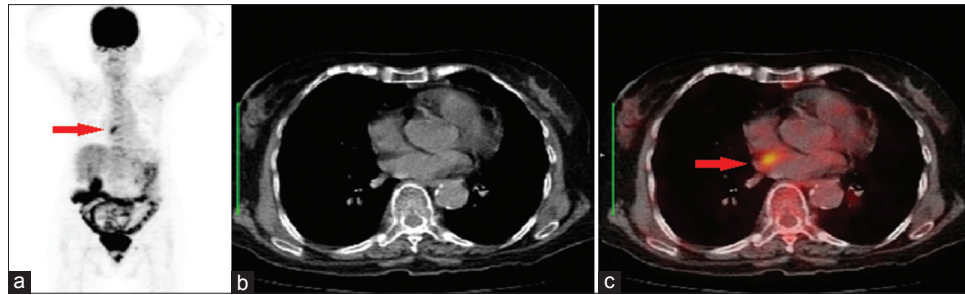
There was increased FDG uptake seen in the interatrial septum with standardized uptake value of 3.5 (a and c). The hypodense interatrial septum measures 6 mm on the corresponding CT images (b). There was neither FDG-avid local recurrence nor evidence of metastases seen elsewhere in the scan. The left apicoposterior lung nodule was not metabolically active
